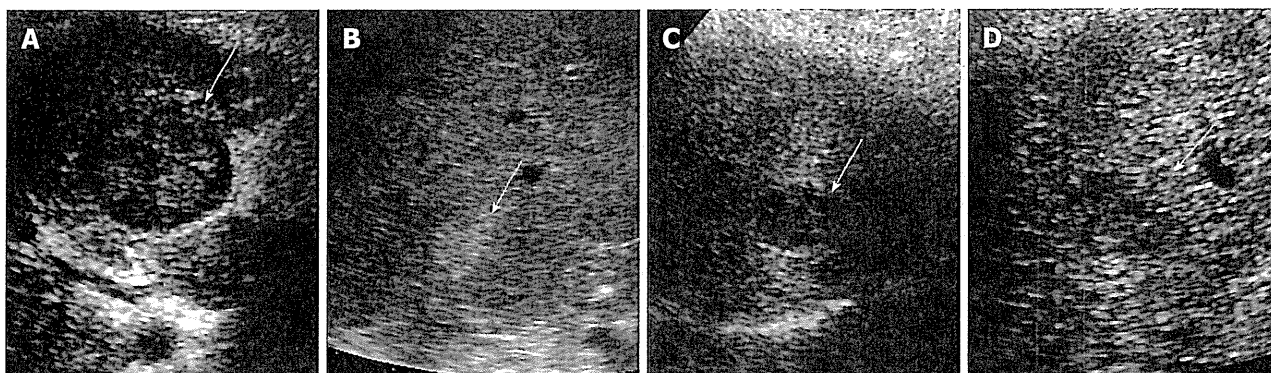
Classification of B-mode ultrasonographic images of small hepatocellular carcinoma. A-D: Hepatocellular carcinoma nodules < 3 cm in diameter were classified into two groups using B-mode ultrasonography: Type 1 with halo (A) and type 2 without halo. Type 2 was then further categorized into three subgroups: Type 2a, homogenous hyperechoic (B); Type 2b, hypoechoic with smooth margins (C); Type 2c, hypoechoic with irregular or unclear margins (D). Hepatocellular carcinoma nodules are indicated by arrows.
